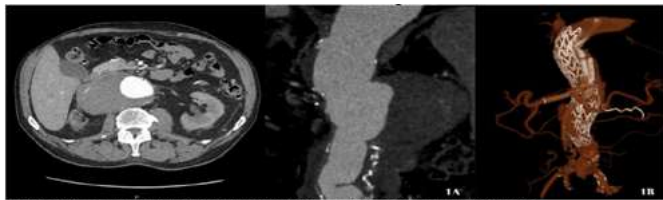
1A - CT scan of anastomotic pseudoaneurysm; 1B - CT reconstruction after CHEVAR.
